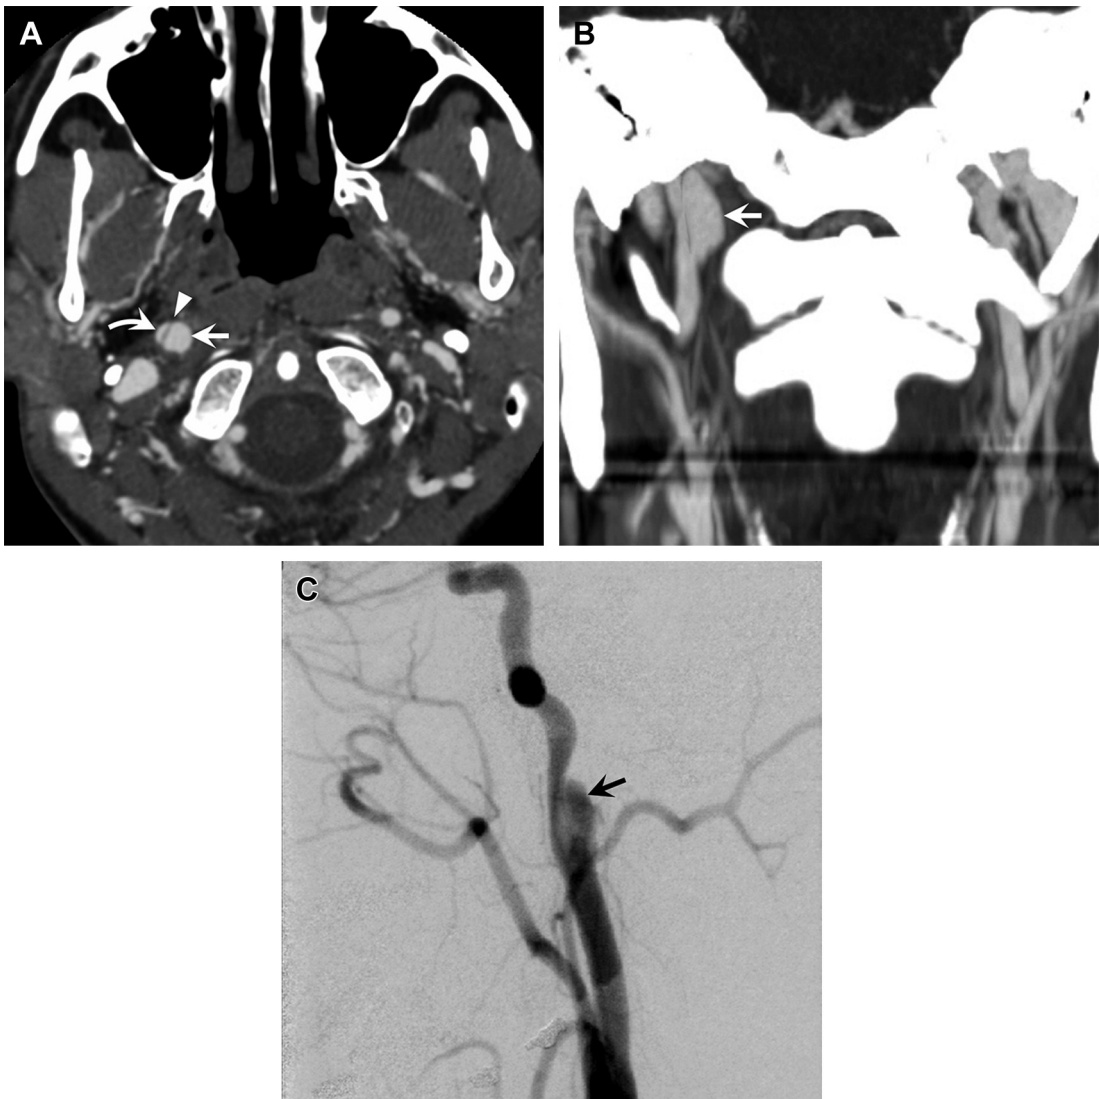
Right internal carotid dissection and pseudoaneurysm. (A) Axial CTA image reveals a dissection flap (*arrowhead*) with a large pseudoaneurysm (*arrow*) that severely compresses the true ICA lumen (*curved arrow*). (B) Coronal 2D reconstructed CTA image and (C) lateral angiogram confirm the dissection, pseudoaneurysm (*arrow*), and compressed true ICA lumen.
